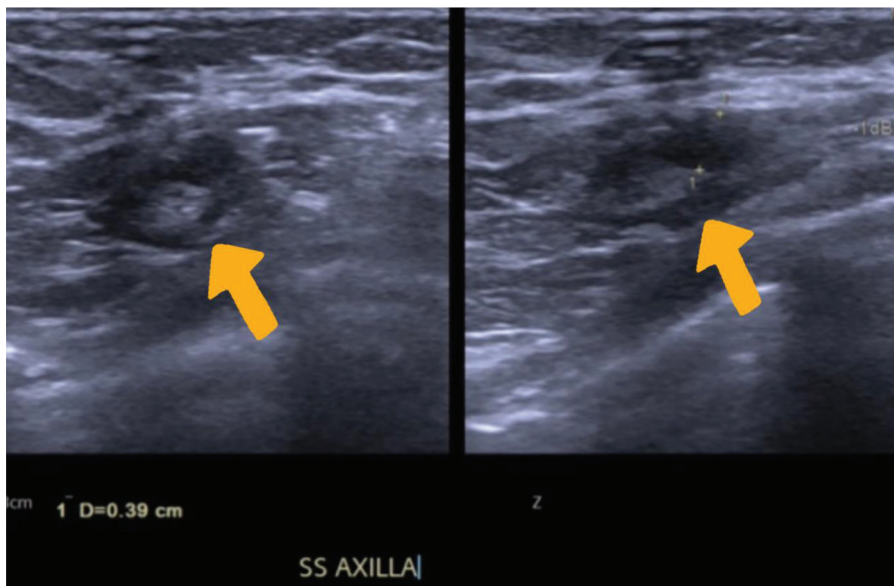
The ultrasound appearance reveals axillary adenopathy characterized by suspicious hypertrophic cortex (arrow), subsequently subjected to ultrasound-guided puncture (which did not reveal signs indicative for malignancy).
